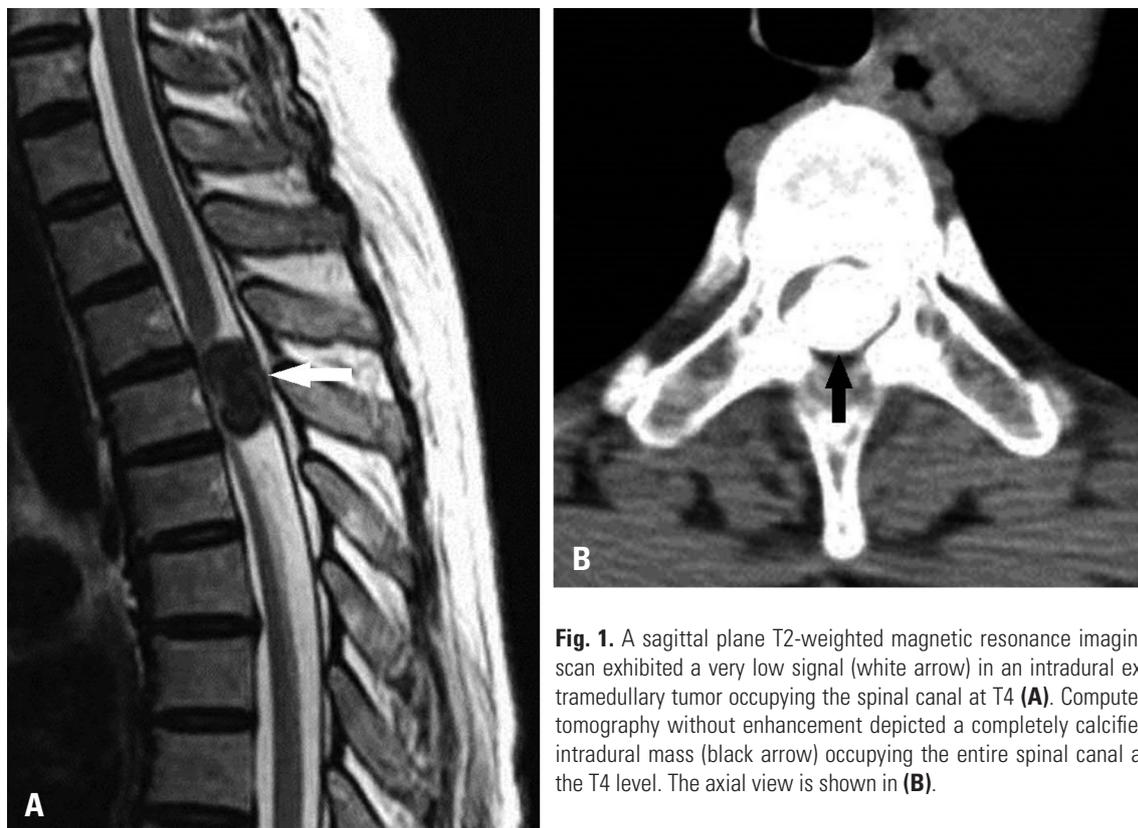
A sagittal plane T2-weighted magnetic resonance imaging scan exhibited a very low signal (white arrow) in an intradural extramedullary tumor occupying the spinal canal at T4 (A). Computed tomography without enhancement depicted a completely calcified intradural mass (black arrow) occupying the entire spinal canal at the T4 level. The axial view is shown in (B).
